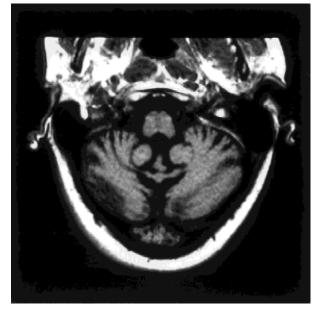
1999 MRI of brain showing cerebellar atrophy.
